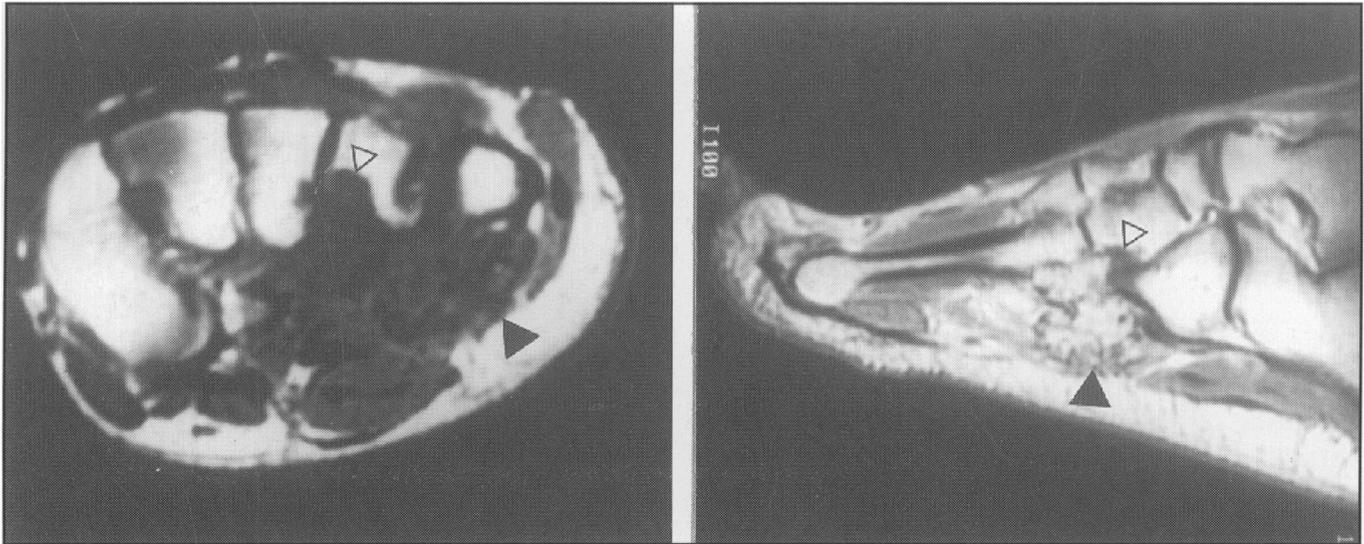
(a). Coronal view T1 weighted MRI Low signal tissue is seen adjacent to the base of the 4th and 5th metatarsals (closed arrow head); it has the same signal strength as the surrounding muscle. Within this region there are multiple foci with very low signal in keeping with calcification. The low signal soft tissue is seen eroding into the plantar aspect of the 4th metatarsal (open arrow head).
